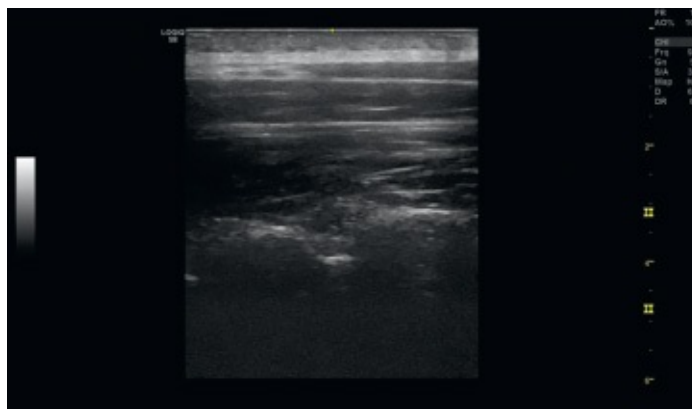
• Ultrasound of the lumbar and thoracic spine for epidural placement.
